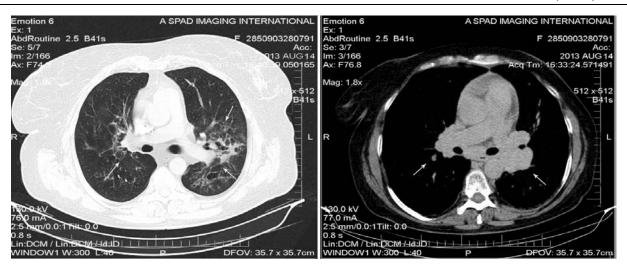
Chest CT showing hilar lymphadenopathy and diffuse fibrosis.
